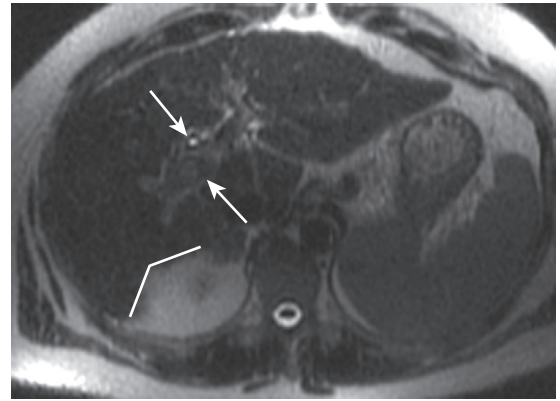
Atrophy-hypertrophy pattern in cirrhosis. The axial heavily T2-weighted image of a cirrhotic liver shows the typical atrophy-hypertrophy pattern resulting in the hepatic notch sign (*angled lines*) due to right lobe atrophy and caudate hypertrophy and prominence of the periportal space (*arrows*) due to medial segment atrophy. Note the nodularity and lateral segmental hypertrophy.
